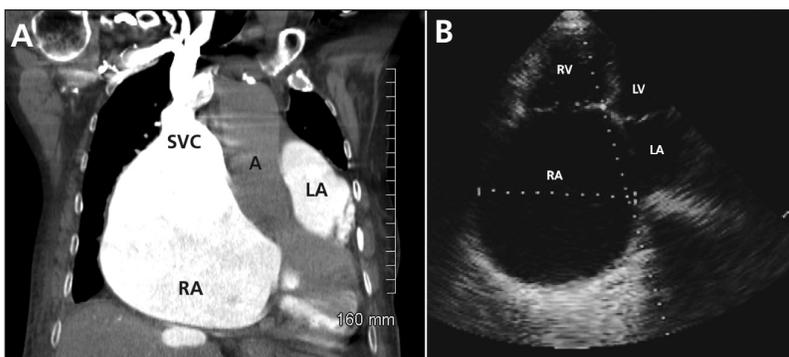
(A) Computed tomography scan of the chest with intravenous contrast in an 84-year-old woman showing marked dilatation of both atria and a prominent superior vena cava (SVC). (B) Echocardiogram (four-chamber apical view [enhanced for print]) showing massive enlargement of the right atrium (RA), a normal-sized left atrium (LA), which is compressed by the right atrium, and a noncoapting tricuspid valve caused by annular dilation. A = aorta, LV = left ventricle, RV = right ventricle.
